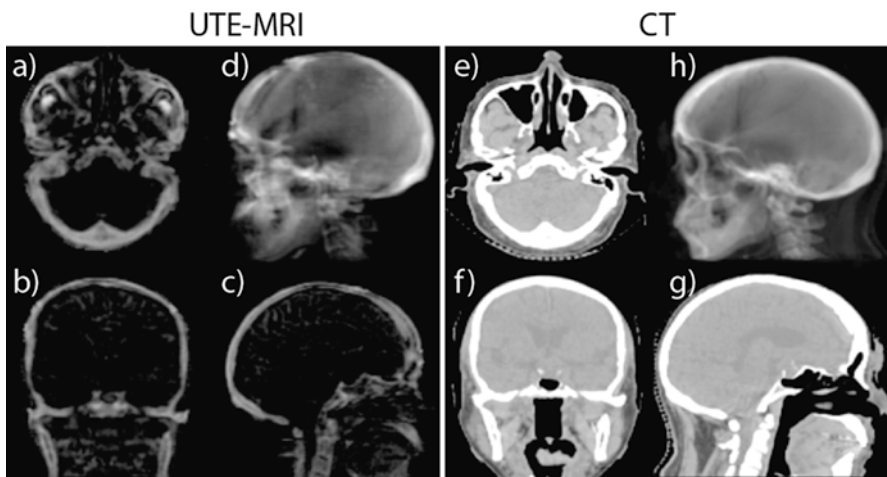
Left:* three orthogonal planes (a–c) of UTE-MRI image showing clear bony anatomy features and a digital reconstructed radiograph (DRR) (d) generated from UTE-MRI. *Right:* three planes of corresponding CT image (e–g) and a DRR (h) generated from CT of the same patient
